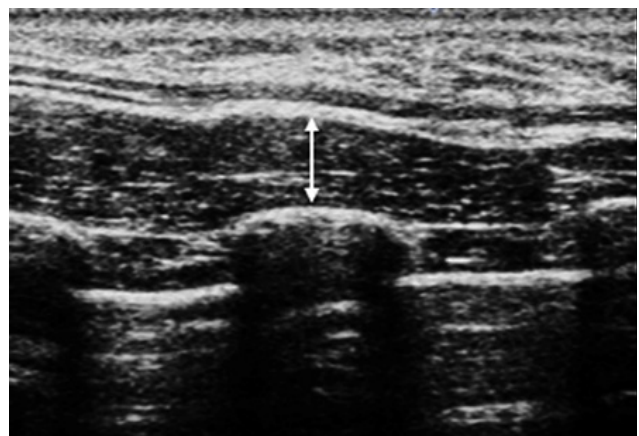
Ultrasound image of serratus anterior muscle. Thickness of serratus anterior was demarcated by a solid white line with arrowheads.
